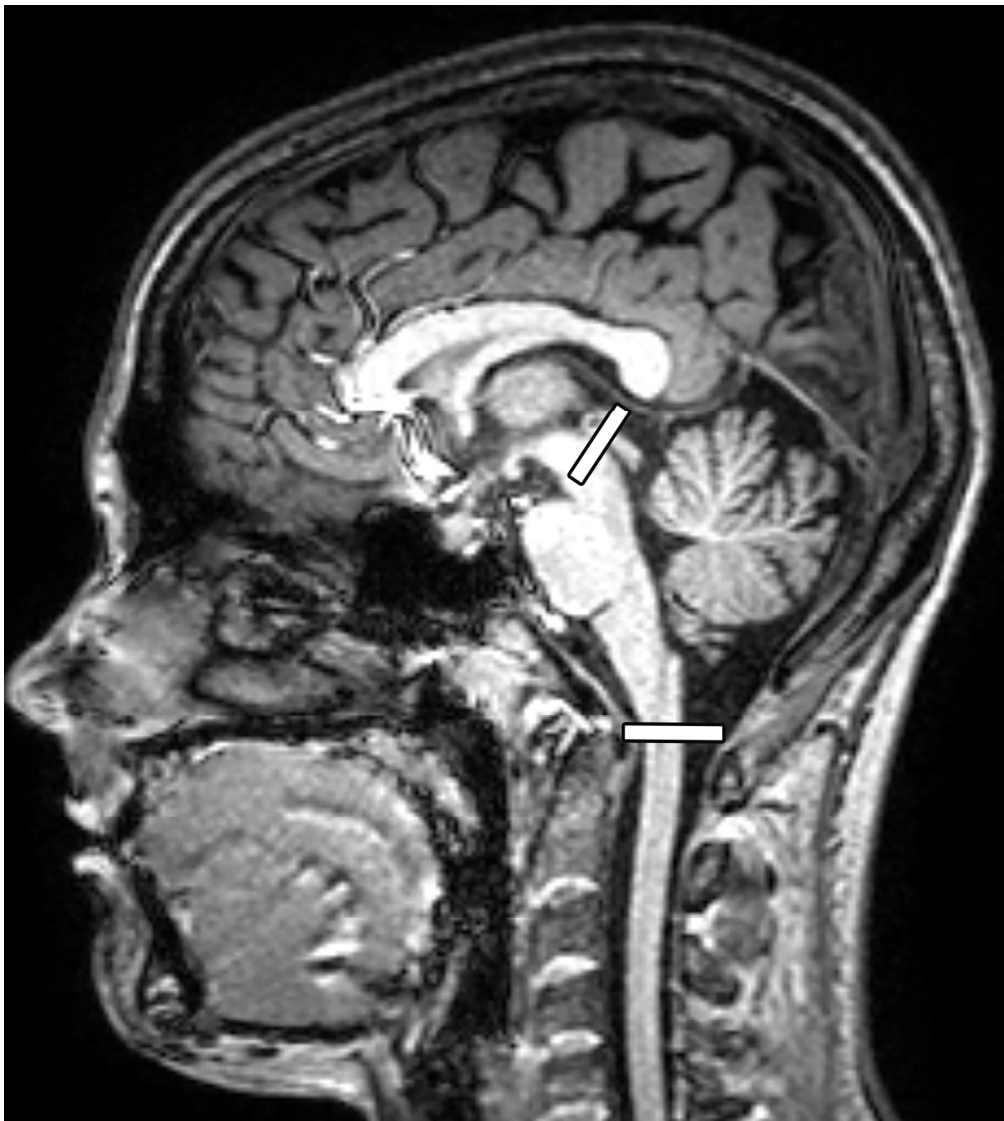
Sagittal T1-weighted MRI of the head and cervical spine, with the neck in the neutral position. Annotations represent the axial plane of phase-contrast CSF flow measurements at the aqueduct and craniocervical junction in a patient with CMI..
